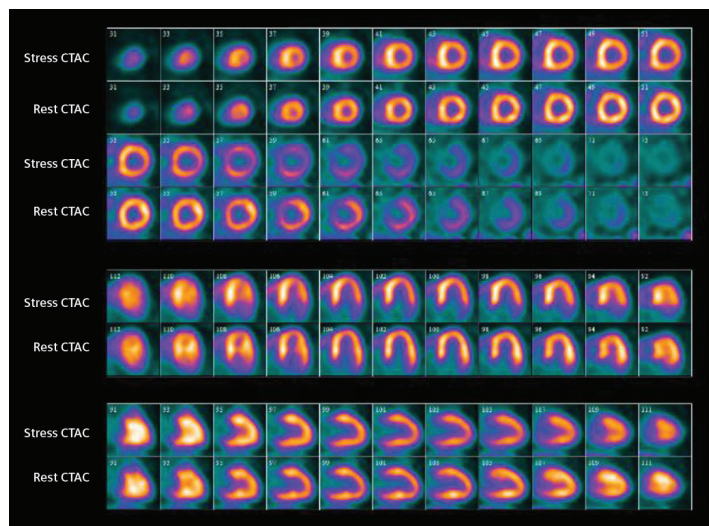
Stress/rest  $^{82}\text{Rb}$  PET/CT myocardial perfusion study shows reversible ischemia in the posterolateral wall.
